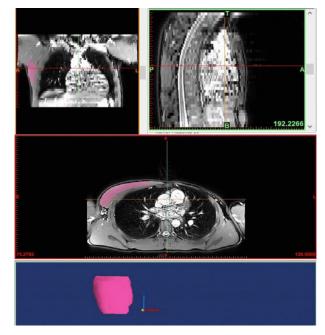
DICOM data elaboration from MRI imaging, identification of pectoralis area (pink highlight) and extrapolation of the pectoralis muscle area
